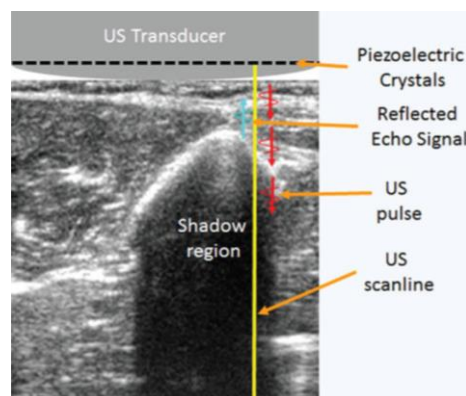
Bone appearance on ultrasound (Retrieved from Hacihaliloglu et al. [55]).
